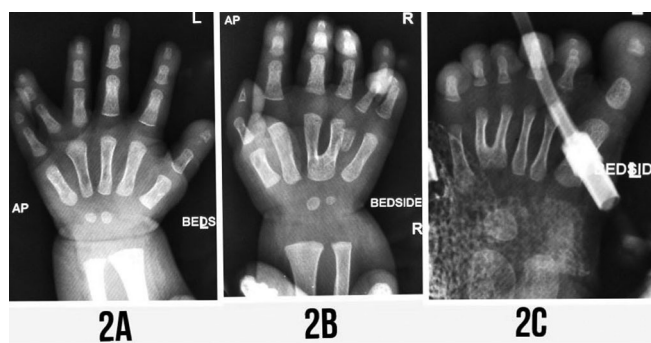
(A). Radiograph of left hand -AP view showing post axial polydactyly of left hand. Note that two digits arising from 4th left metacarpal. (B). Radiograph of right hand- AP view showing post-axial polydactyly of right hand with Y-shaped 3rd right metacarpal. Also note the right 4th under-developed metacarpal. (C). Radiograph of left foot-AP view showing post axial polydactyly. Also note Y-shaped 4th metatarsal.
